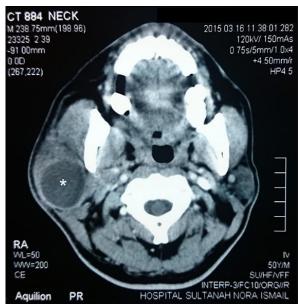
CT scan of neck shows there was a well-defined, rimenhancing, hypodense lesion measuring 4cm x 3cm x 4cm in the right parotid gland, with Hounsfield unit (HU) ranging 29 to 35. Lesion is marked with *.
